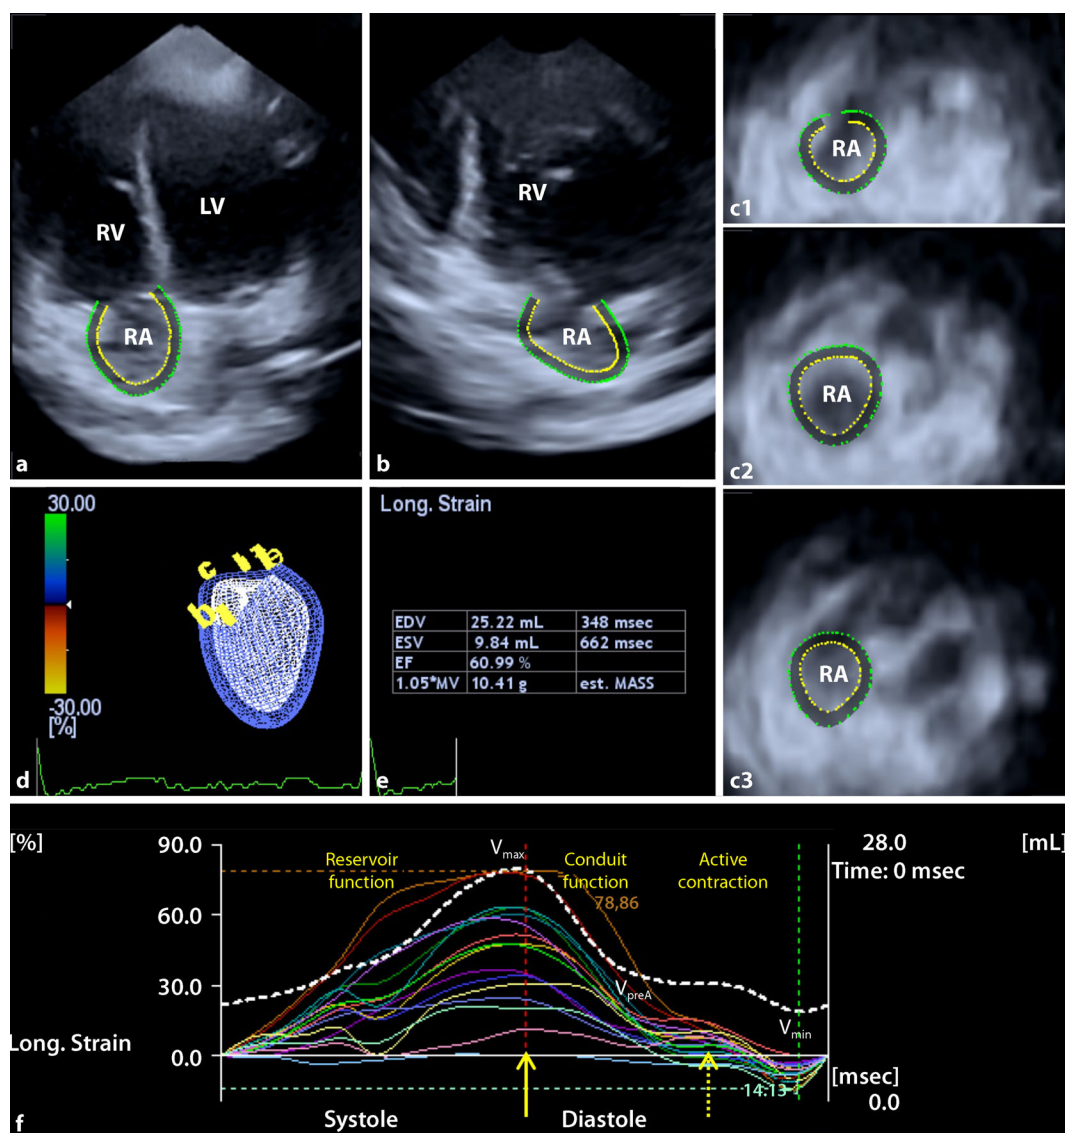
◀ Apical four-chamber (a) and two-chamber views (b) as well as short-axis views at the basal (c1), mid- (c2), and superior (c3) right atrial level derived from a three-dimensional echocardiographic dataset. A virtual model of the right atrium (d) and its volumetric data (e) during the cardiac cycle together with time-segmental strain curves of all right atrial segments and time-volume changes during the cardiac cycle (f). The yellow arrow represents peak strain, while the dashed arrow represents strain at atrial contraction. V_{max} , V_{min} , and V_{preA} represent systolic maximum and diastolic minimum right atrial volumes and right atrial volume before atrial contraction, respectively. LV left ventricle, RV right ventricle, RA right atrium
